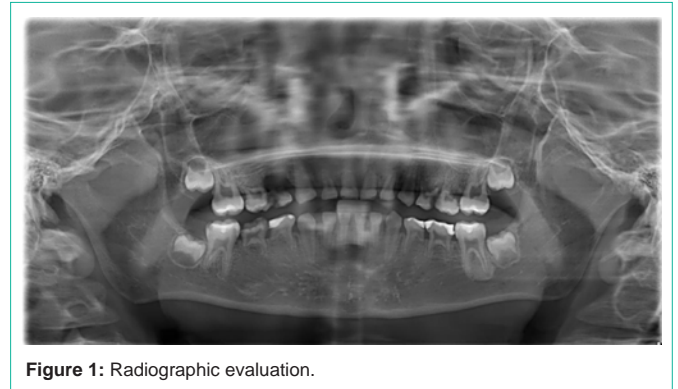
Radiographic evaluation.
